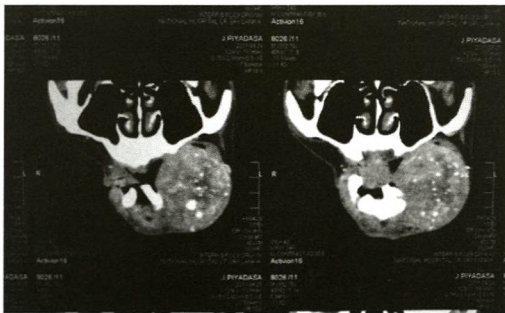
Coronal view of the CT Scan showing pressure erosions of left side maxilla and calcifications within the tumour.
